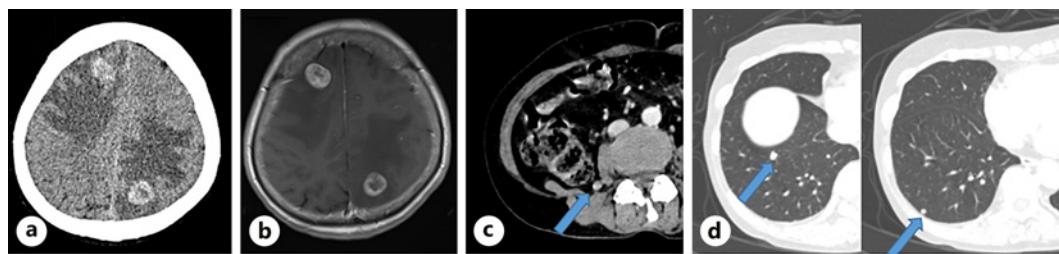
a Computed tomography (CT) demonstrated two high-density lesions with surrounding edematous changes in the right frontal and parietal lobes. b Magnetic resonance imaging (MRI) demonstrated two tumors in the right frontal and left parietal lobes. c CT demonstrated a 7 mm nodule with a contrast effect on the outer side of the right psoas muscle. d CT demonstrated multiple nodules in the lower lobe of the right lung.
